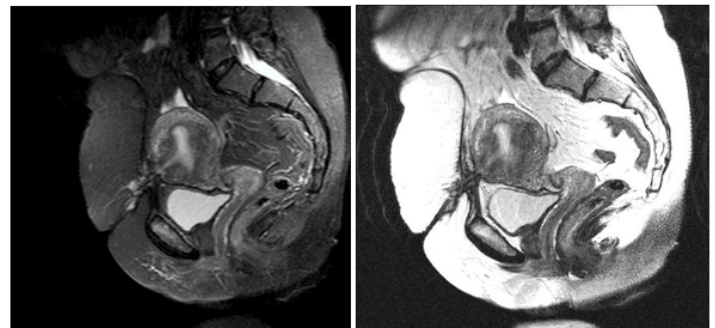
Pelvic MRI scan showing the communication between anterior abdominal wall and the uterine cavity.
